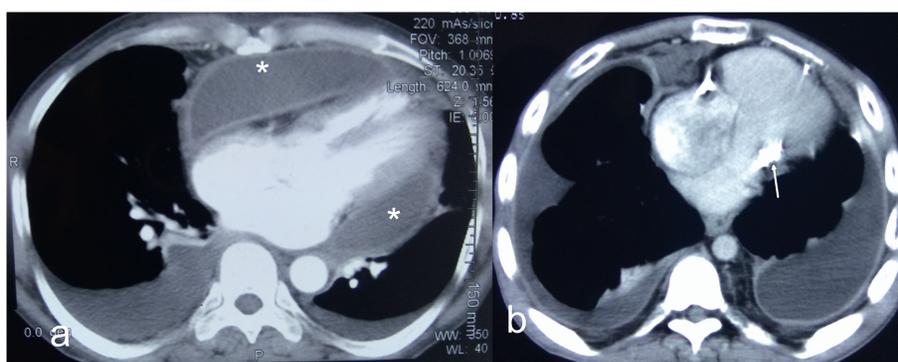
CT chest showing (a) thickened pericardium with loculations (asterix) and (b) annular calcific constriction (arrow).
